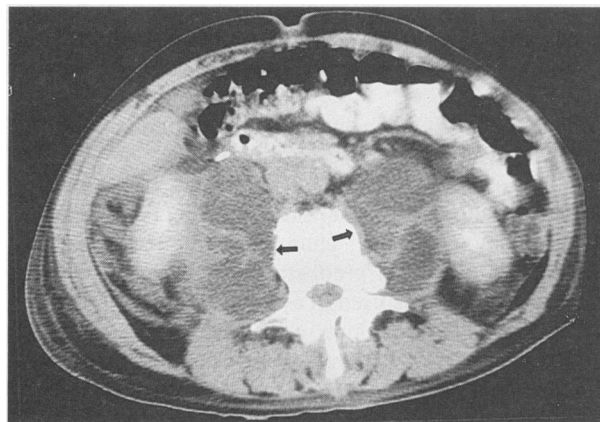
An abdominal computed tomographic scan shows bilateral psoas abscesses (arrows).
